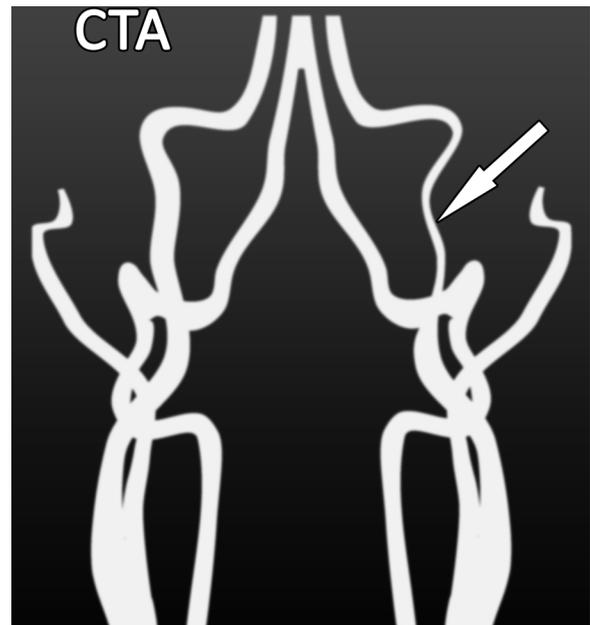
Scheme of CT angiogram (CTA) of CAD; long narrowing of the left ICA (arrow 1).
